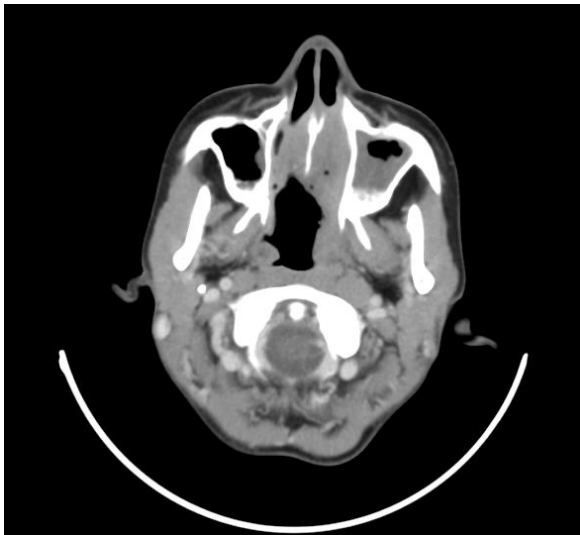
CT scan of the paranasal sinuses axial view showing an irregular enhancing lesion in the region of hard palate with erosion of palatine process of both maxilla and nasal septum
